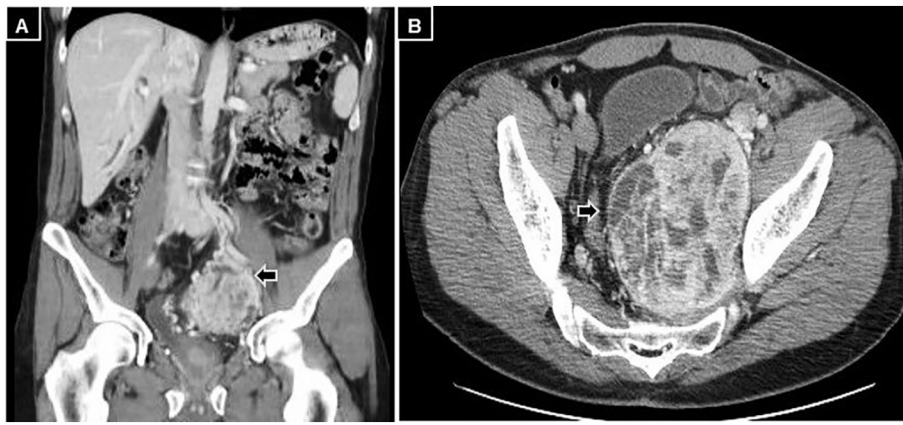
Abdominal and pelvic CT in arterial phase. A: An increase of highlighted areas to the tumor center alternating with others without contrast uptake suggesting collagenization spots is observed (black arrow). B: The tumor presents zones with early marked enhancement, which begins at the periphery. Besides, fat planes of rectum separation are observed (black arrow).
